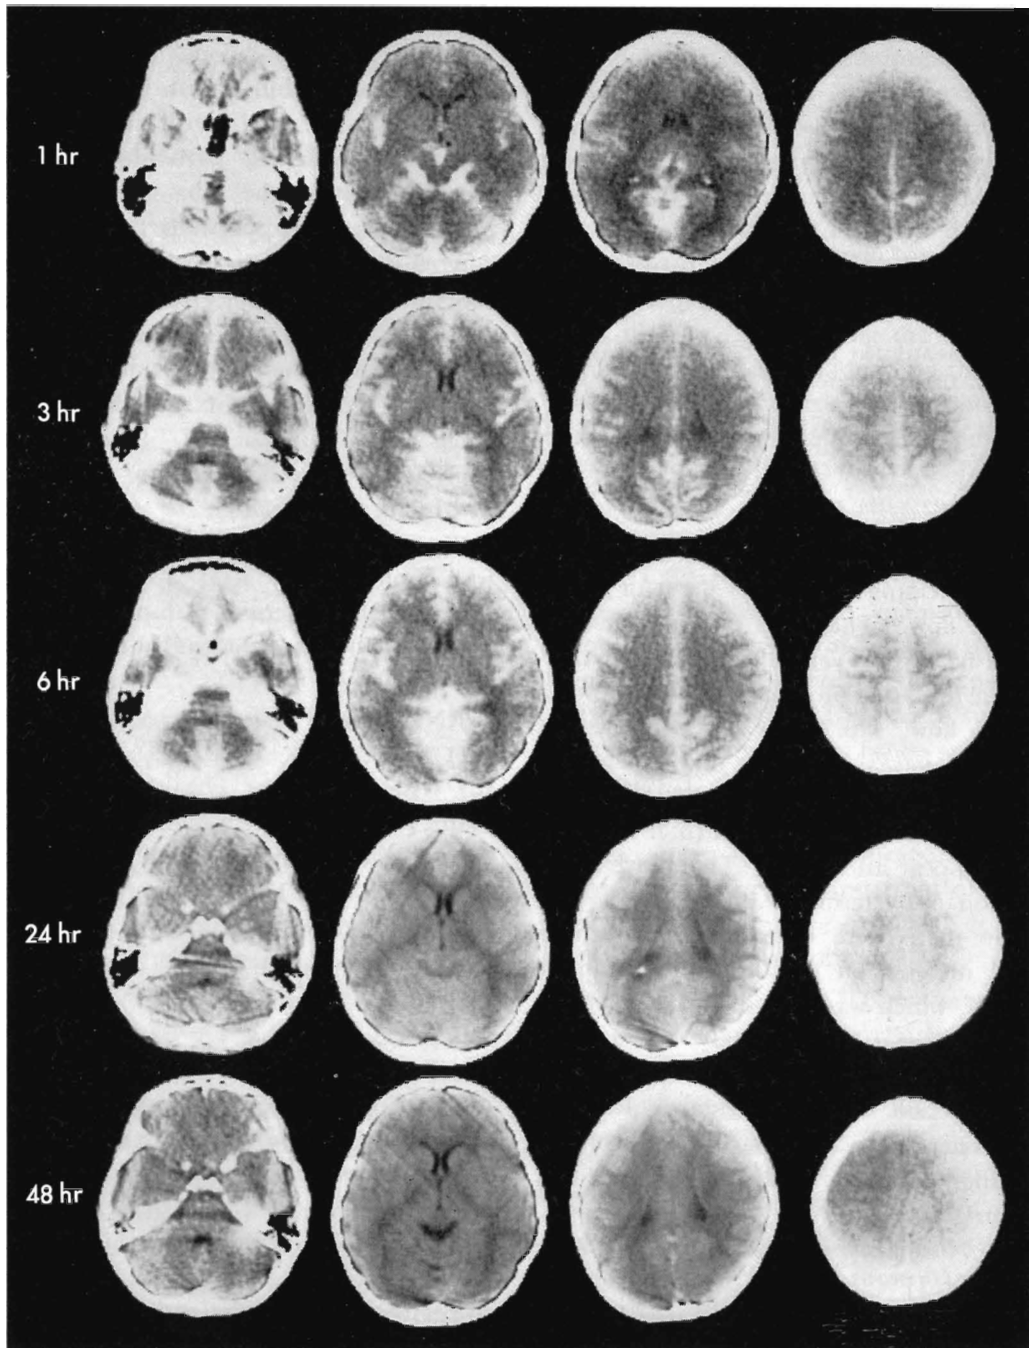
CT cisternograms taken at 1, 3, 6, 24, and 48 hr after metrizamide injection. Normal pattern (III-B type)
